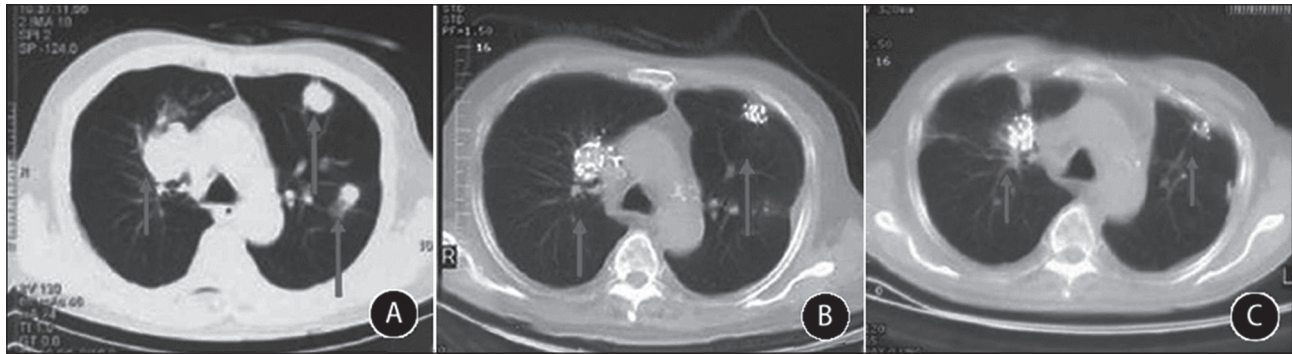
CT before and after osteosarcoma pulmonary metastasis treatment. A: bilateral pulmonary multiple metastasis before treatment; B: metastasis aggregated and tumor size decreased after the 2nd course; C: tumor size was further reduced after the 4th course.
